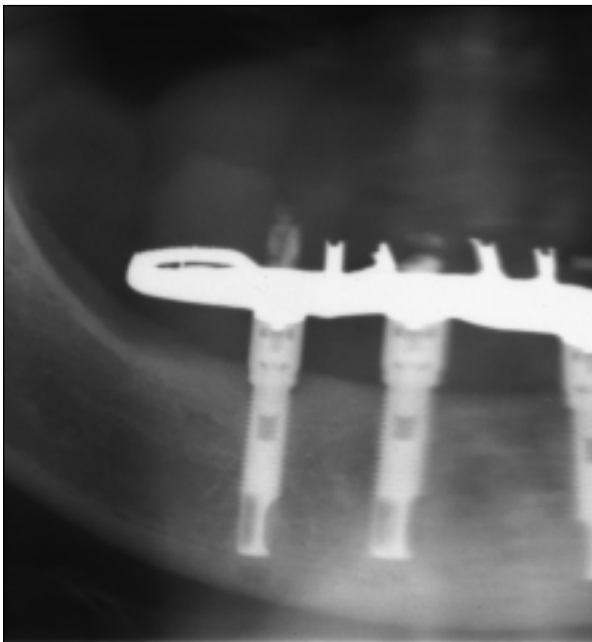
to 3d Radiographs showing the increase in the height of the bony alveolar crest in patient 3.
